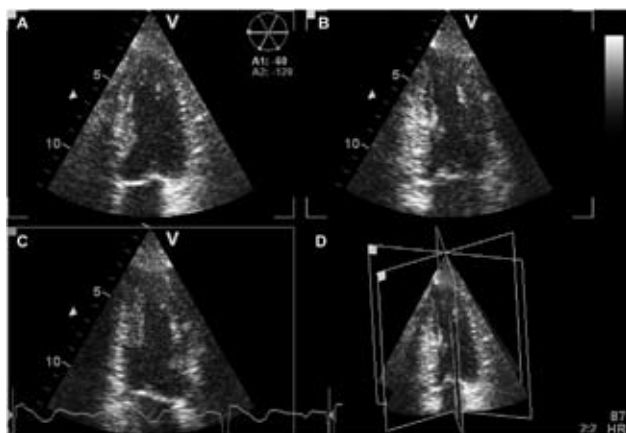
Multiplane (triplane) 3D echocardiography allows simultaneous visualization of 3 apical views. During image acquisition, a 4-chamber reference view (panel A) is chosen and displayed in the upper left corner of a quad-screen image display while secondary imaging planes (2- and 3-chamber views) are simultaneously displayed (panels B and C respectively). The interplane angles are chosen as 60° by default, but can be steered electronically to any desired angle (panel D).
